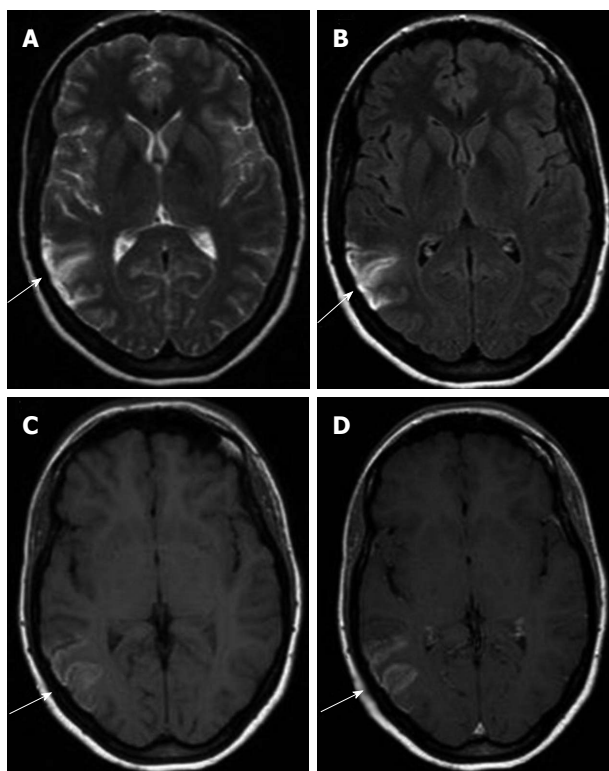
Magnetic resonance imaging at day 20 after ictus: Axial T2-weighted (A), fluid-attenuated inversion-recovery (B) and T1-weighted (C) sequences show high hyperintense cortical lesion (arrows). Minimum enhancement on Axial T1 post-contrast (D).
